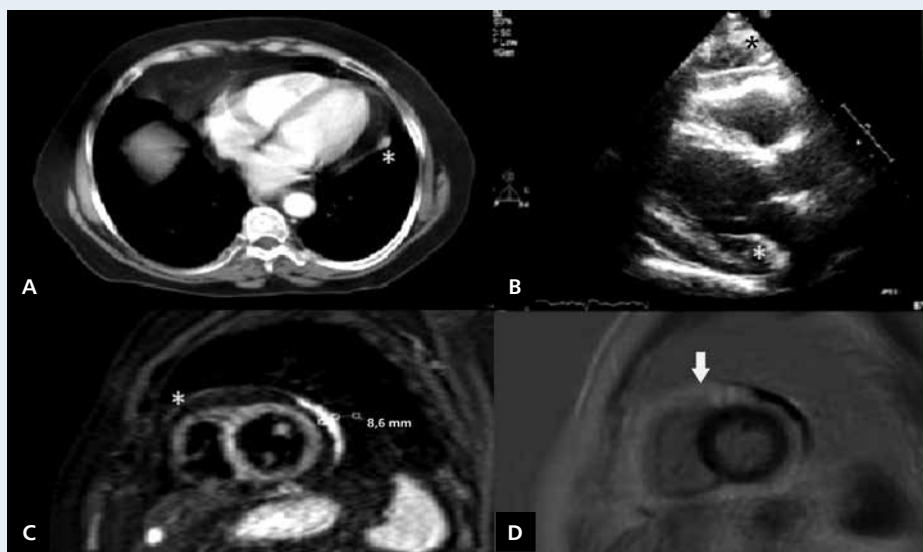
A. Computed tomography revealed cardiomegaly and hypodense area surrounding the heart (asterisk: adipose tissue); B. Echocardiography showed echogenic area in the neighbourhood of all heart chambers (asterisk: adipose tissue); C. T2 fat suppressed short axis imaging showed epicardial fat tissue (asterisk) and localised pericardial thickness upon the lateral wall of left ventricle; D. The lack of contrast enhancement in contrast and PSIR short axis cardiac magnetic resonance imaging; arrow — epicardial adipose tissue
